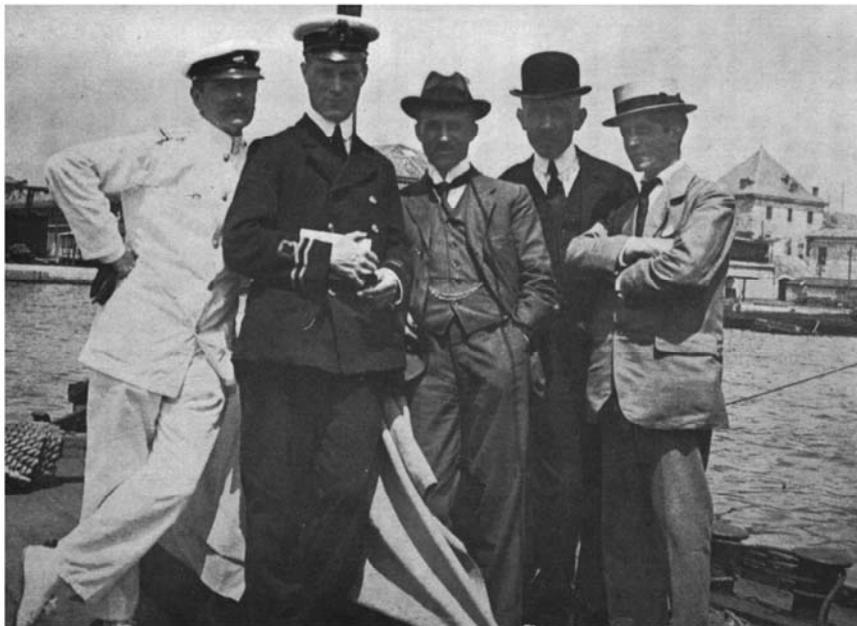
Members of the French and British teams for ultrasonic submarine detection. Summer 1917, Toulon dockyard. L to R. Capitaine de Frégate Colin, Lt R Saville, Robert Boyle, Paul Langevin, Marcel Tournier.
